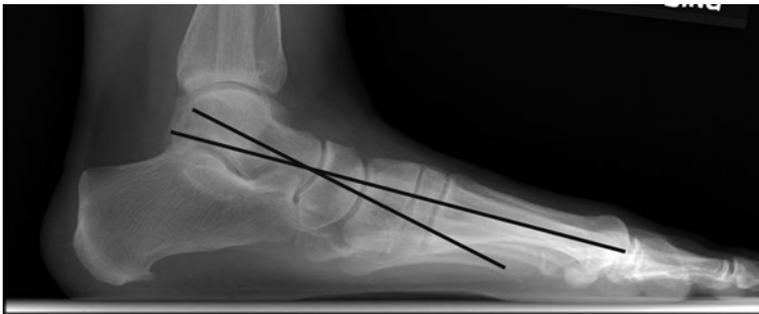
Lateral weight-bearing radiograph of a patient with posterior tibial tendon dysfunction. Note the plantarflexed position of the talus relative to the first metatarsal
